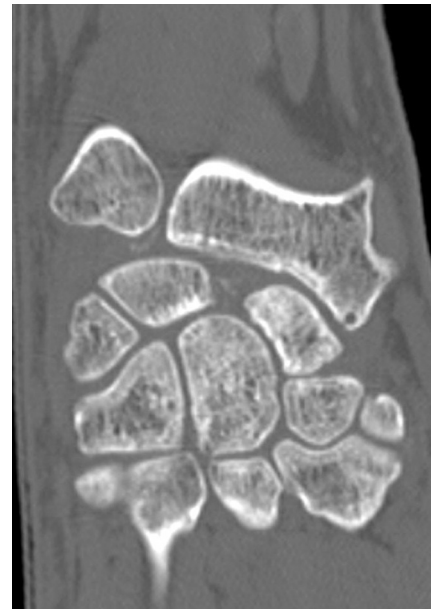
Coronal CT slice of the left wrist.
